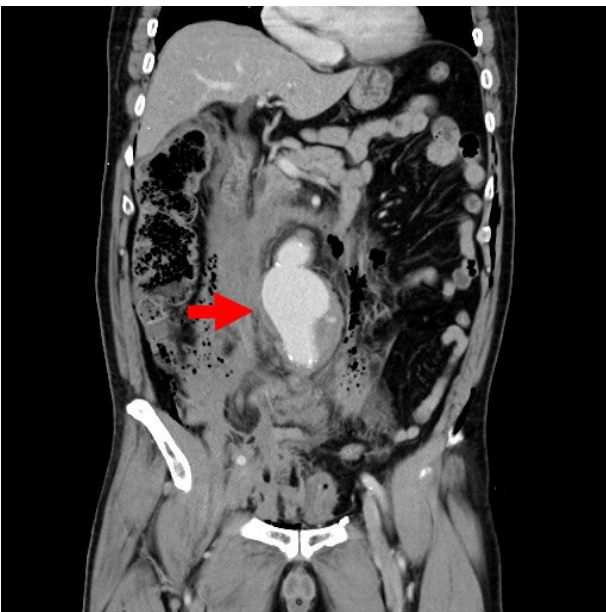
Abdominal computed tomography (CT) an hour after herniorrhaphy demonstrating a retroperitoneal hematoma suggestive of a ruptured infrarenal abdominal aortic aneurysm (arrow).
